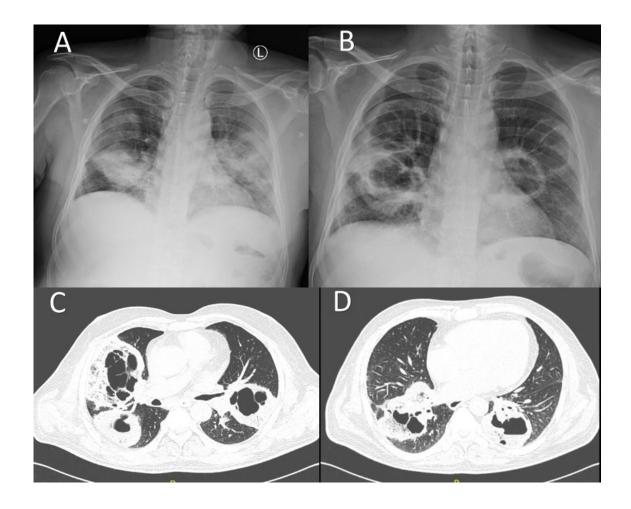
A,B) Chest roentgenograph at admission and 8 days later. C,D) CT thorax showing bilateral cavities with peri-cavitary consolidation.
